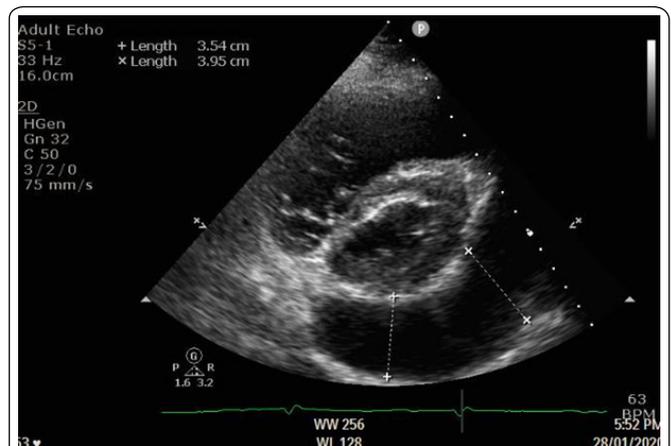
Loculated, regional LV pericardial effusion (parasternal short-axis view).
